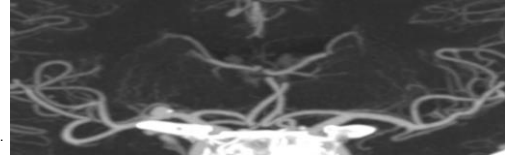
Case 2 A) Brain CT scan showing hyperdensity in the M1 segment of the left middle cerebral artery (MCA). B) CTA confirmed left MCA occlusion and showed a proximal left internal carotid artery (ICA) dissection. (F) (C) CT perfusion showing an area of increased MTT in the left hemisphere. (D-E) MRI scans 2 days after treatment showed areas of FLAIR signal hyperintensity (E) with restricted diffusion (D) in the left deep grey nuclei and in the cortex of insular and temporo-parietal gyri, representing ischemic stroke
